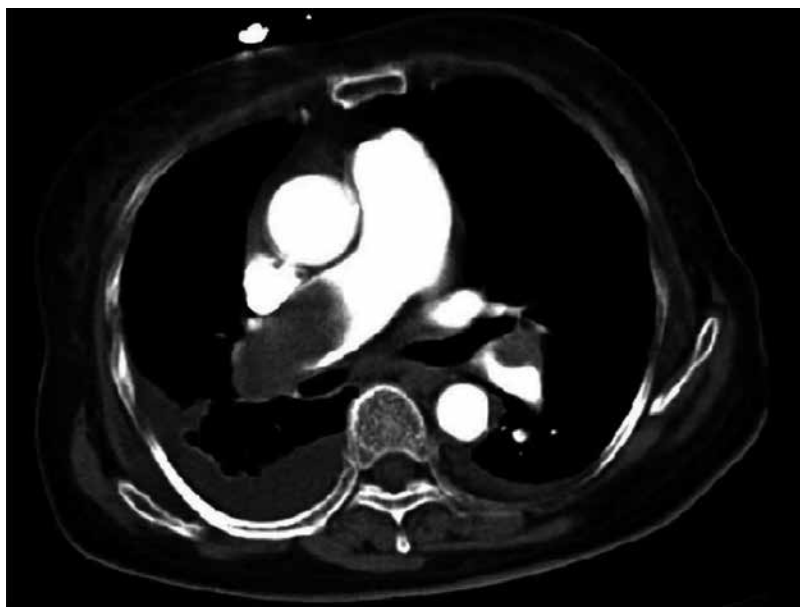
Massive PE as appears in contrast enhanced CT chest.
